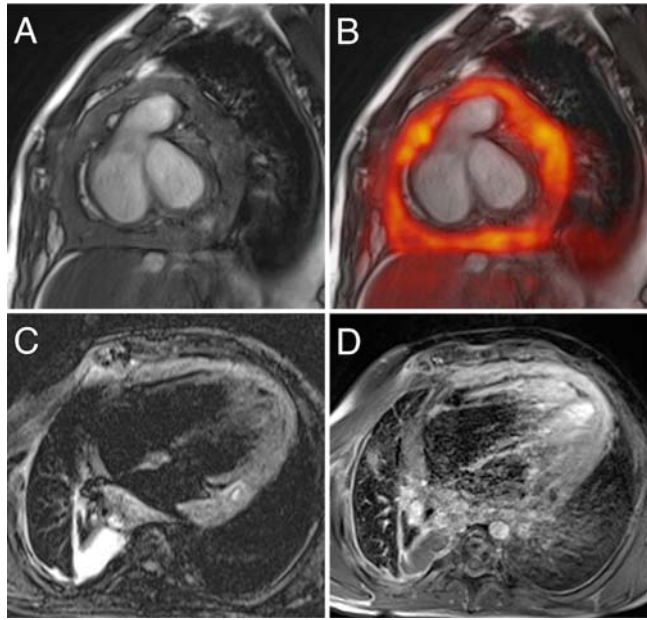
SSFP image (A) of a patient with local relapse of cardiac Ewing's sarcoma (Table 1, Patient 5) showing massive pericardial infiltration with intense FDG uptake (fusion B, SUV_{max} 14.6). T2-weighted images demonstrated hyperintensity of the tumor masses (C) and post-contrast T1-weighted images showed significant contrast enhancement (D).
